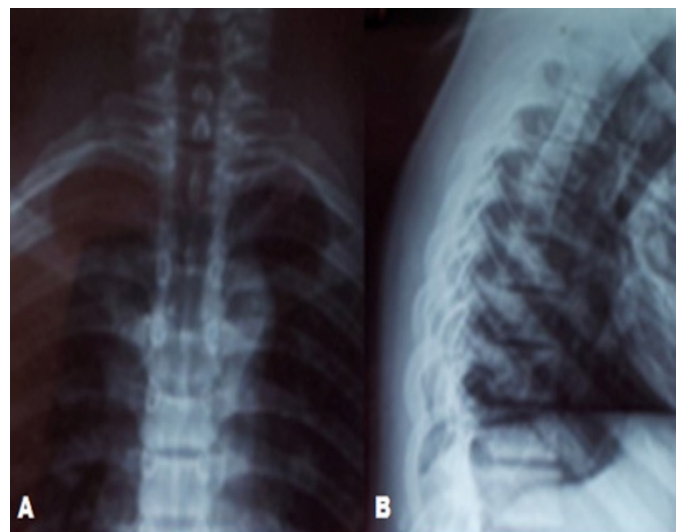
Radiograph of the thoracic column in anteroposterior (a) and lateral (b) views, respectively
